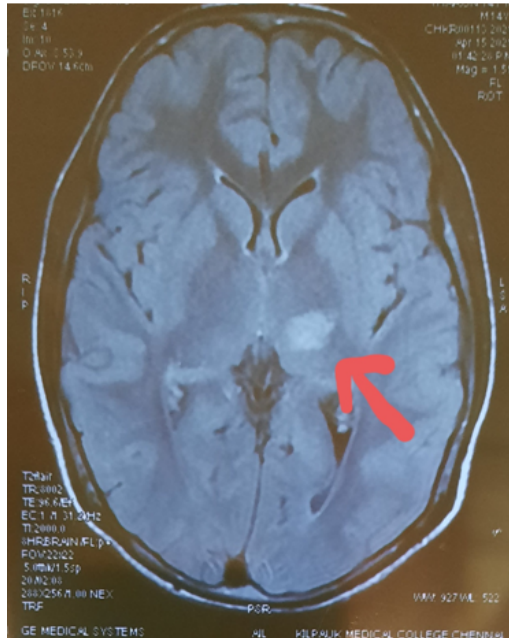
T2/FLAIR hyperintensity in left thalamus
